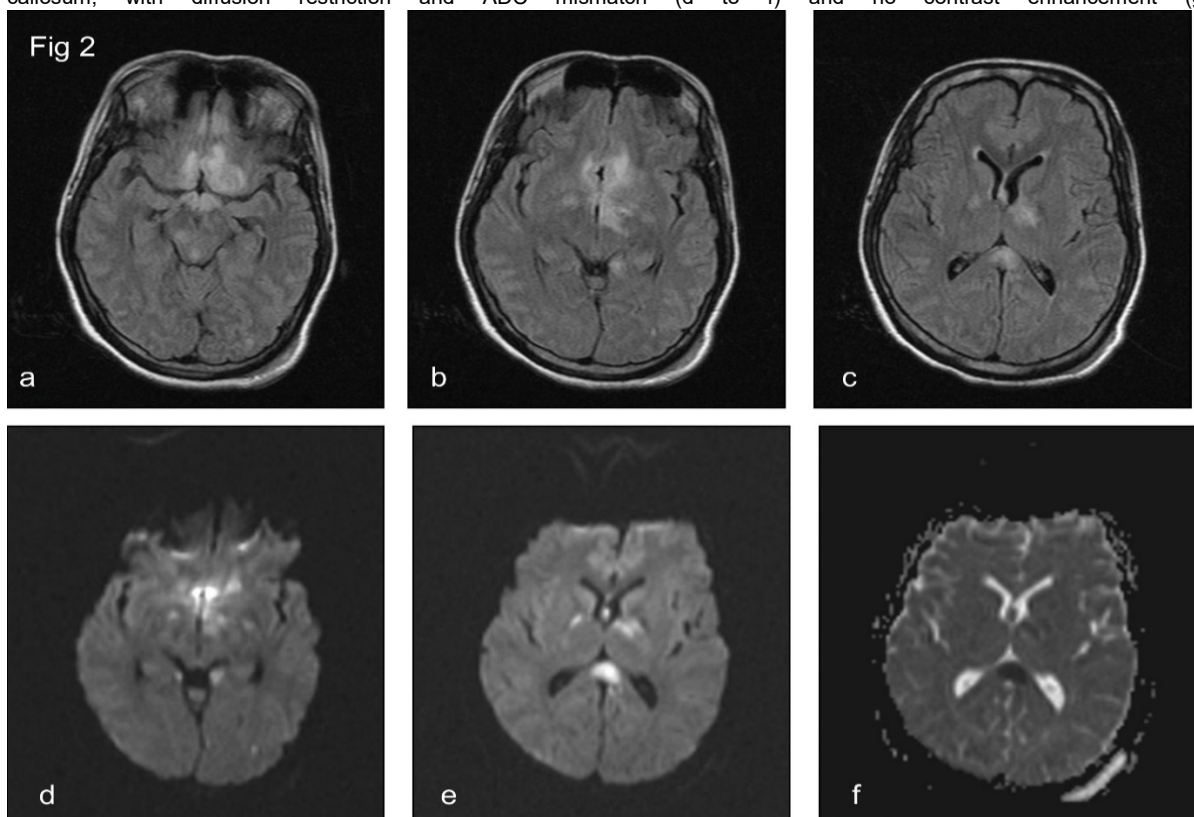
Repeat MRI Brain on day 6 of illness showing an increase in FLAIR hyperintensities as compared to previous MRI in fig 1 (a to c) with additional involvement of anterior column of fornices, medial temporal lobe, genu of the internal capsule on the right side & midbrain with diffusion restriction and ADC mismatch (d to f).
